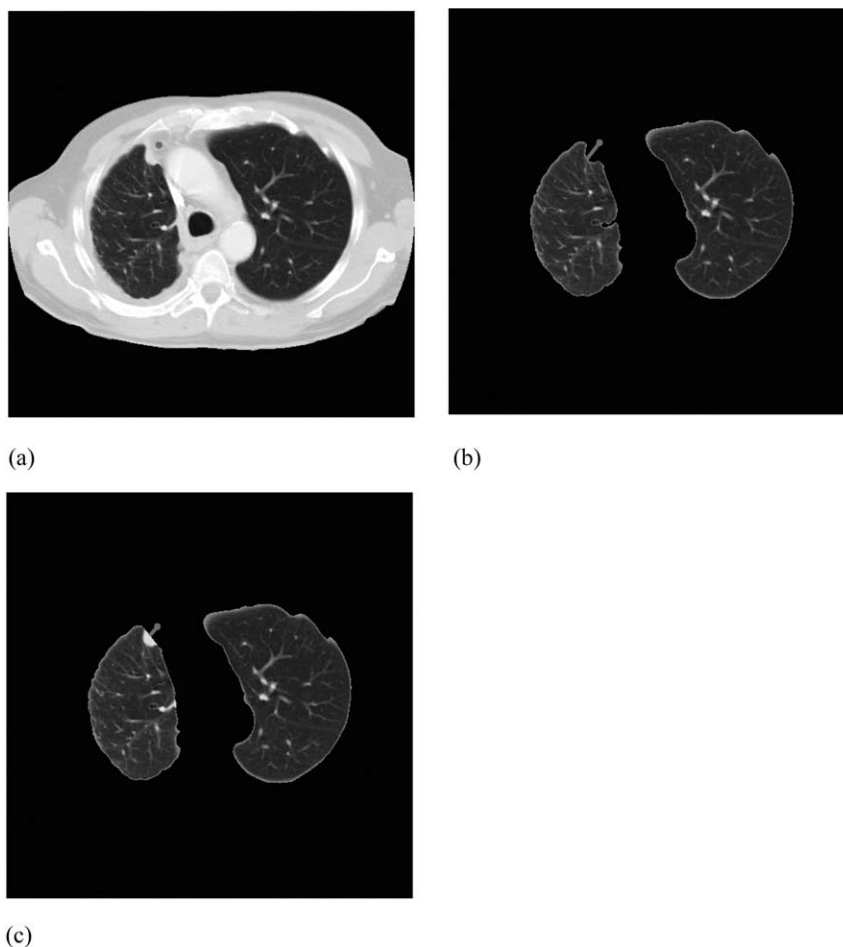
(a) Original computed tomography section demonstrating mesothelioma in the right hemithorax. A user-selected point along the outer tumor margin is shown at a desired measurement site (gray dot in white hemithorax). (b) The lung segmentation region generated by the core segmentation method allows a semiautomated thickness measurement that correctly spans the tumor. (c) With the rolling ball algorithm implemented, the boundary of the resulting lung segmentation region does not provide an appropriate surrogate for the inner tumor margin, and an underestimate of tumor thickness results.
